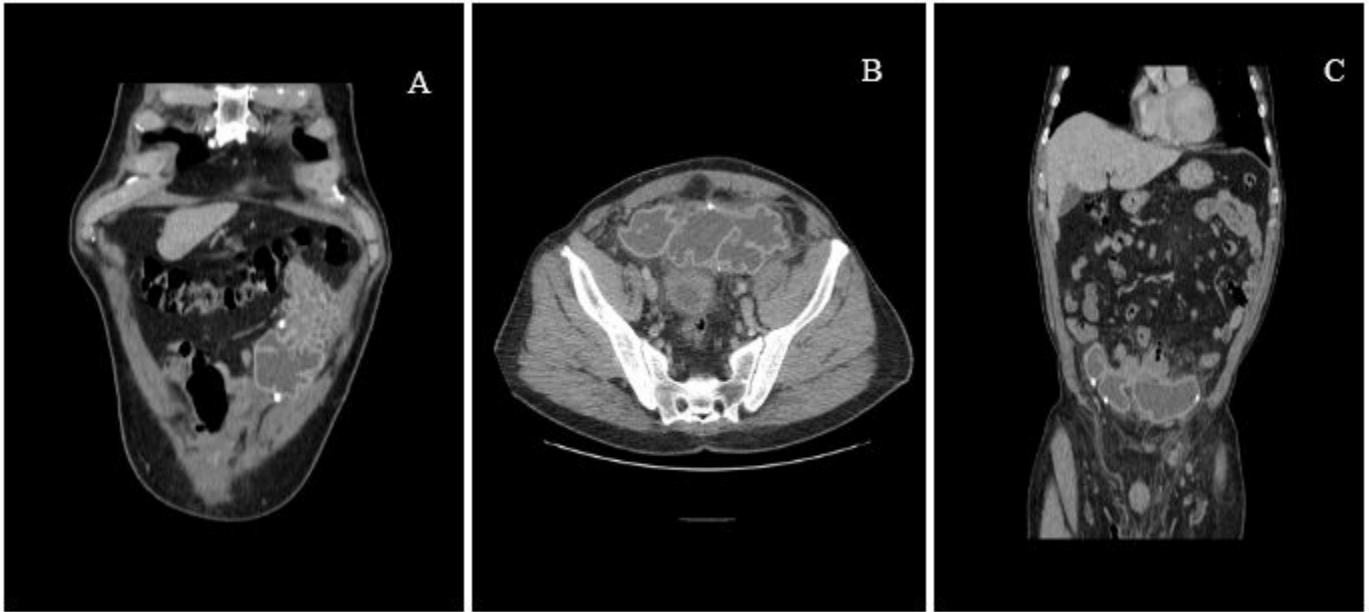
(A) Coronal reformatted contrast enhanced computed tomography reveals liquid collection in left upper quadrant. Axial (B) and (C) coronal reformatted contrast enhanced computed tomography reveals liquid collection in pelvis. Note thick hyperdense undulating walls of collections with a few tuckers on both images.
